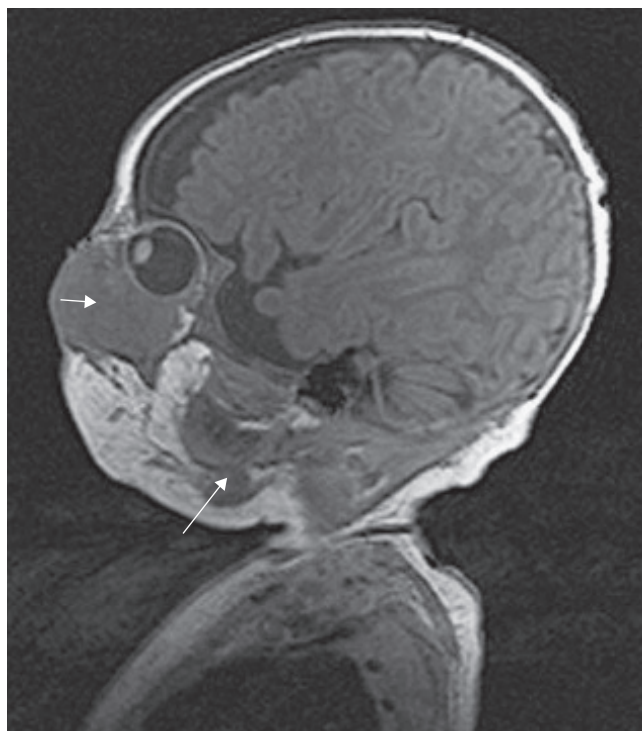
Paramedian T1-weighted MRI scan through the left orbit of a 3-month-old boy. There is a huge mass of rhabdomyosarcoma in the anterior orbit (short arrow) displacing the globe and submandibular lymphadenopathy (long arrow).
